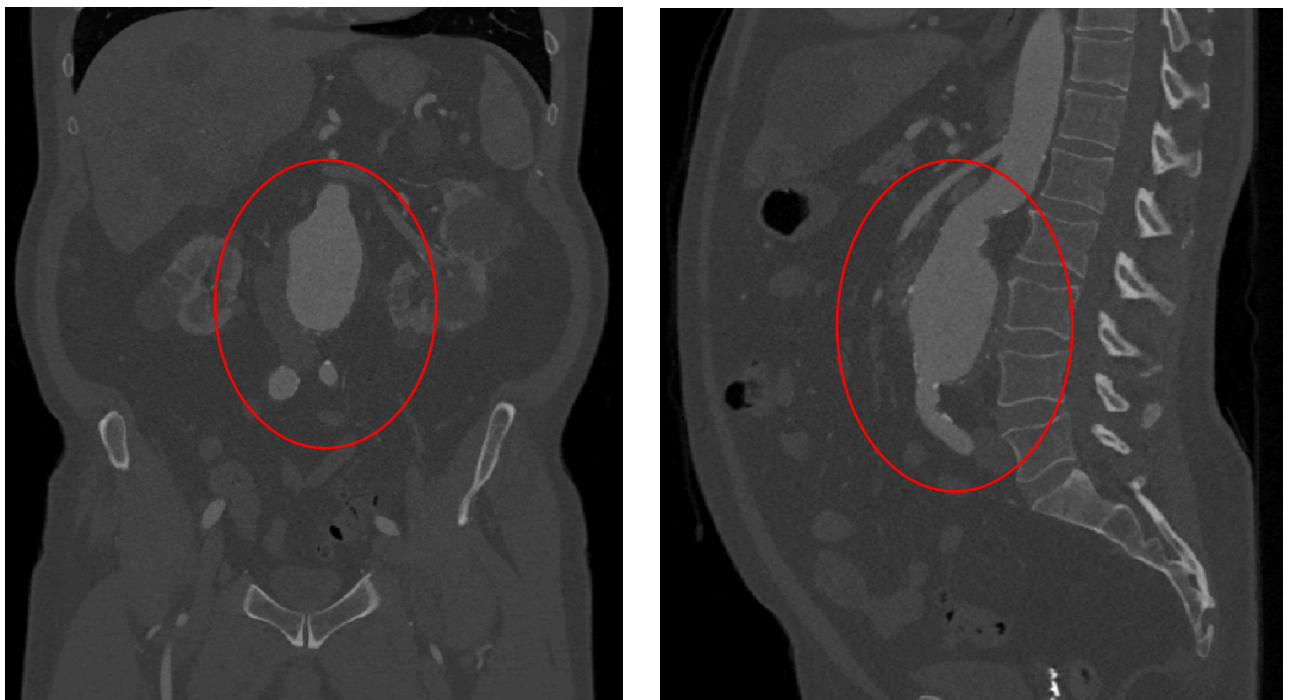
CT-scan of one of the included subjects. The aneurysm is visible within the red circle. Left: Coronal slice. Right: Sagittal slice.
